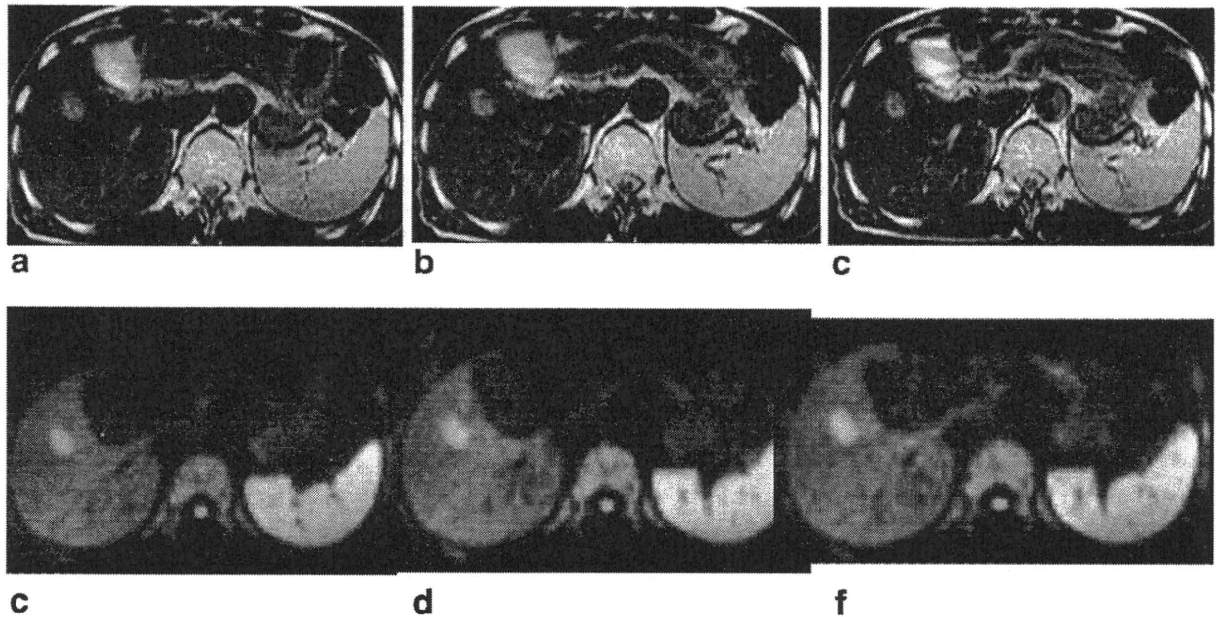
A 79-year-old man with HCC. The difference in conspicuity between pre- and postenhanced images was not that significant. a: Pre-enhanced T2-weighted image. b: Postenhanced T2-weighted image (after 4 min). c: Postenhanced T2-weighted image (after 20 min). d: Prediffusion-weighted image. e: Postenhanced diffusion-weighted image (after 4 min). f: Postenhanced diffusion-weighted image (after 20 min).
